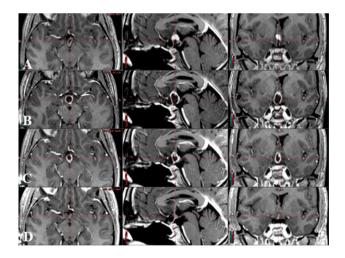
Postradiotherapy transient cyst expansion is shown for a 37-year-old patient with papillary craniopharyngioma after subtotal resection and postoperative radiotherapy. Residual tumor is identified by red crosshairs. (A) Postoperative, preradiotherapy magnetic resonance image (MRI) with residual cystic tumor with enhancing cyst walls. (B) Three-month postradiotherapy MRI shows transient cyst expansion. The patient remained asymptomatic and continued close follow-up. (C) Five-month postradiotherapy MRI shows spontaneous cyst regression. (D) Forty-two-month postradiotherapy MRI shows minimal residual enhancing tissue with no residual cyst
